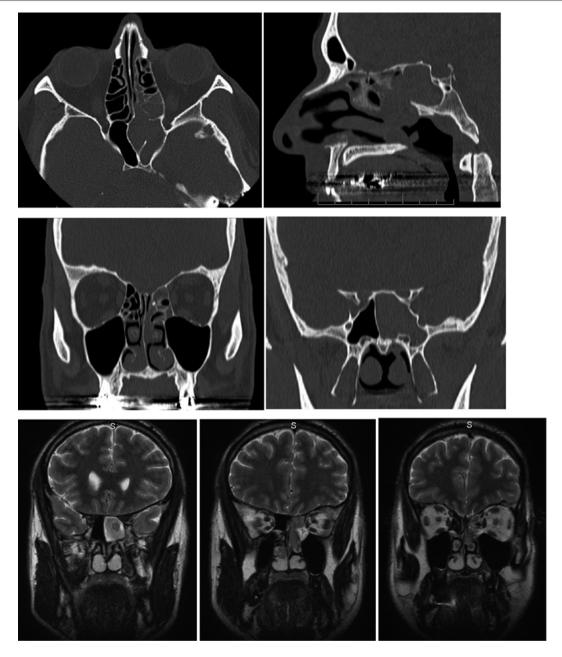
A 50-year-old male patient with sinonasal mucosal melanoma (axial, coronal, and frontal CT scan and frontal MRI views showing the mass). DOD 2 years after diagnosis
